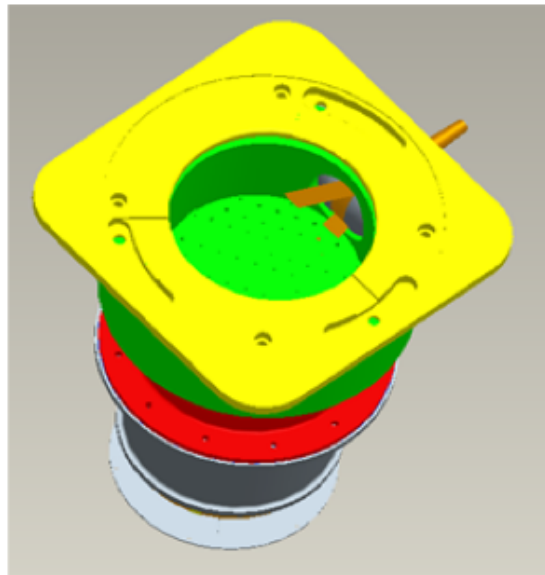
Dual scanner with Ultrasound on the side with depicted rays of the acoustic path.
